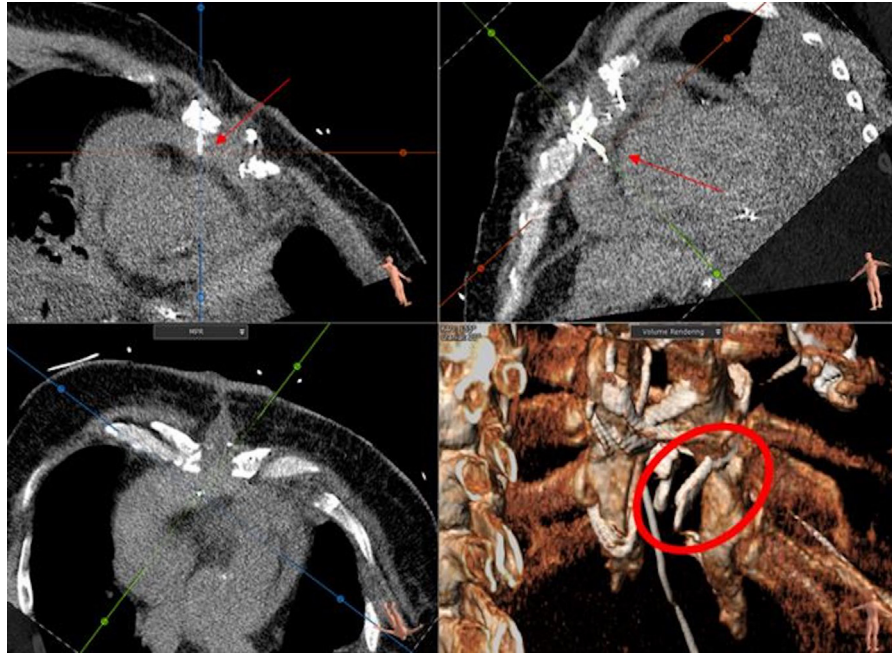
Chest CT, without contrast, multiplanar reconstructions focusing on the sternal wires, demonstrating a fractured sternal wire puncturing the anterior pericardium in oblique frontal (*top left*), oblique sagittal (*top right*), and oblique axial (*bottom left*) displays. The volume-rendered three-dimensional display (*bottom right*) carefully highlights the sternal fracture with sharp wires (*red circle*).
